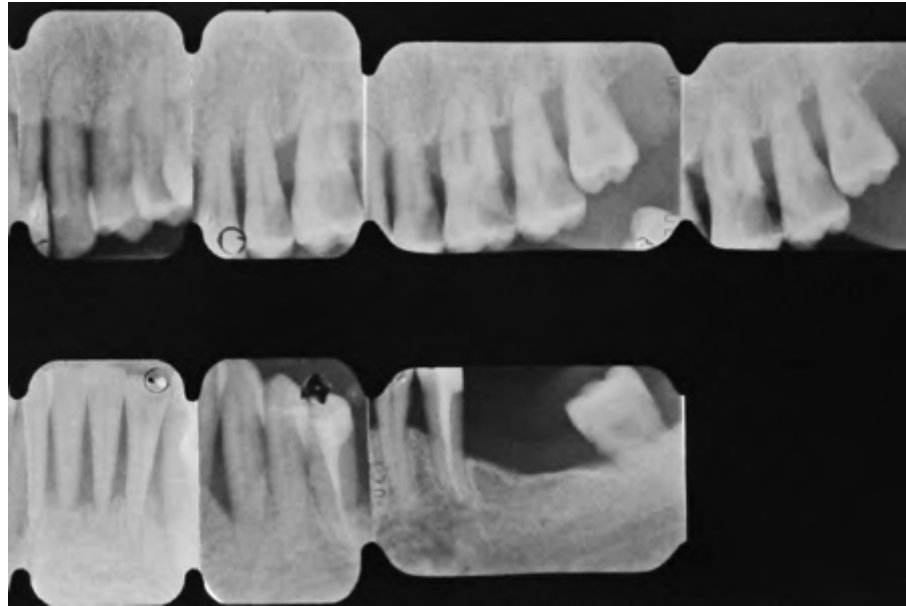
Preoperative periapical radiographs of the left posterior quadrants.
